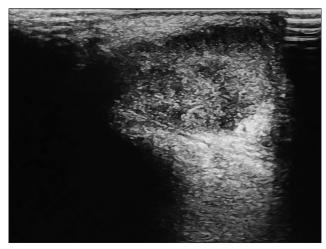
Grayscale ultrasound of a right postauricular swelling with a score of 3/9. USG diagnosis was of a benign lesion but HPE revealed malignancy (deposit of squamous cell carcinoma in lymph node)
